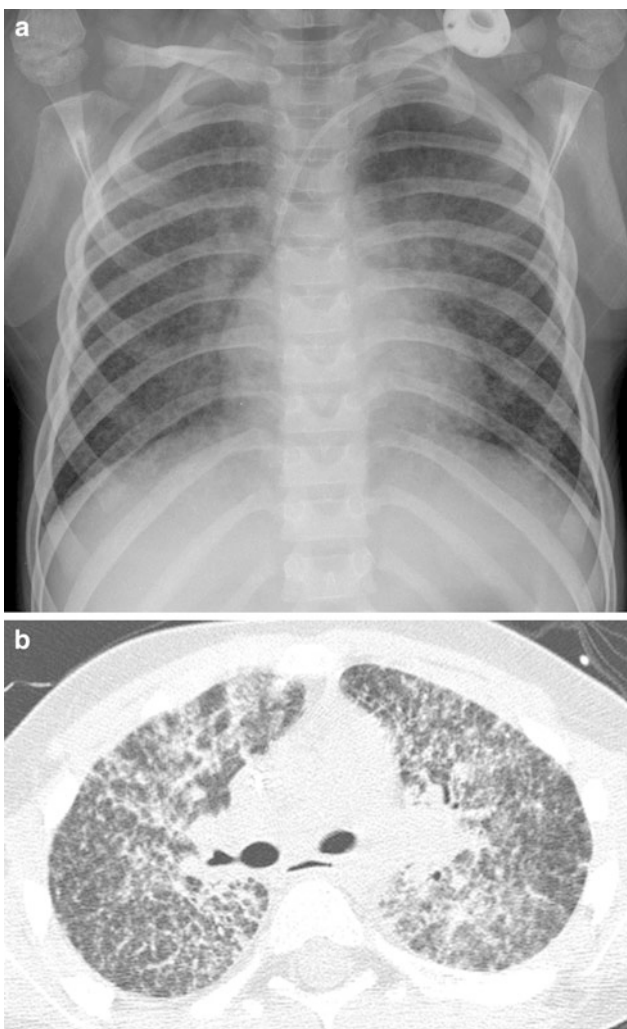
Pneumocystis jirovecii* pneumonia (PCP). A frontal CXR (a) and an axial chest CT image (b) from a 5-year old with acute lymphoblastic leukemia undergoing maintenance chemotherapy show diffuse reticulonodular opacities with a central predominance
